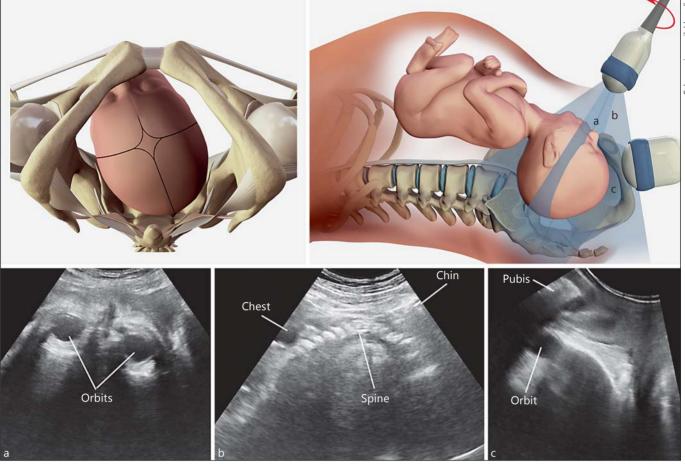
Occipitoposterior presentation (normal head flexion). Upper left panel: graphic representation of the findings useful for the diagnosis with palpation; the small fontanel and the occipital bone are found in the posterior pelvis. Upper right panel: technique of intrapartum sonography: the transducer is initially positioned on the lower maternal abdomen in a transverse plane (a) to demonstrate the orbits; it is then aligned with the fetal nose and rotated 90 degrees to demonstrate the fetal profile (b); eventually, it is positioned below the publis at the level of the labia (c). Bottom panel:
